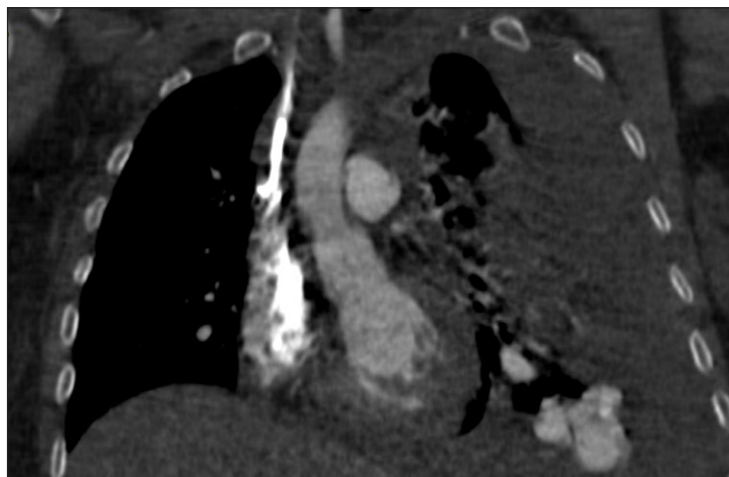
CT image of the AVM, front scan.
